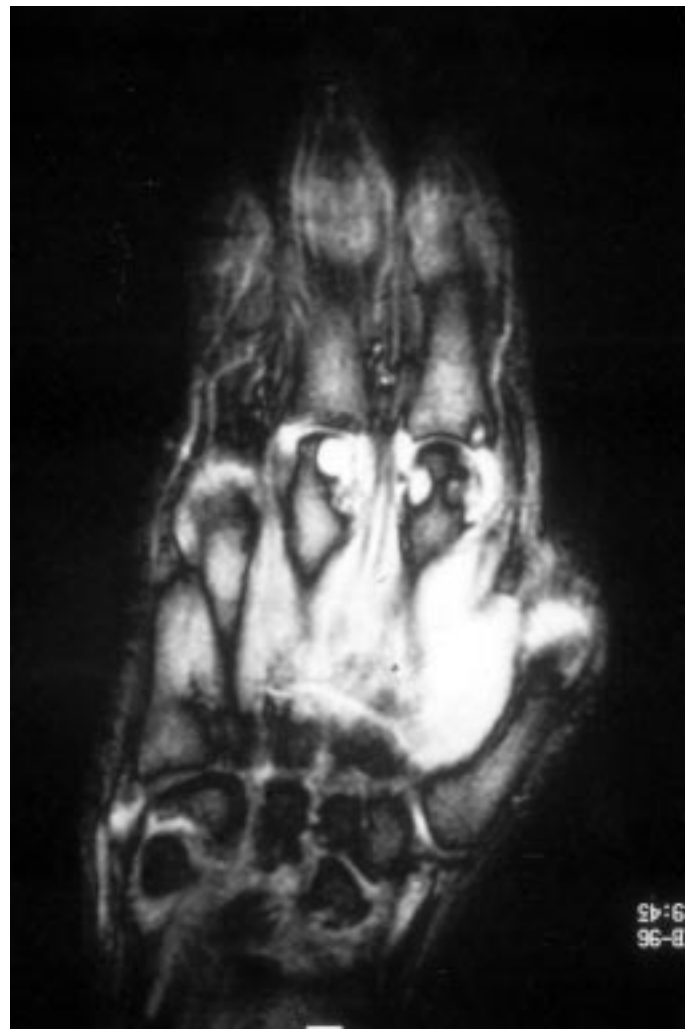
MRI T2* gradient echo recall coronal sequence (field of view of 18 cm, 6 mm slice thickness, repetition time = 420 ms, echo time = 18 ms): synovitis of the wrist, MCP 1–4, PIP 2, 3, and flexor tendons.
